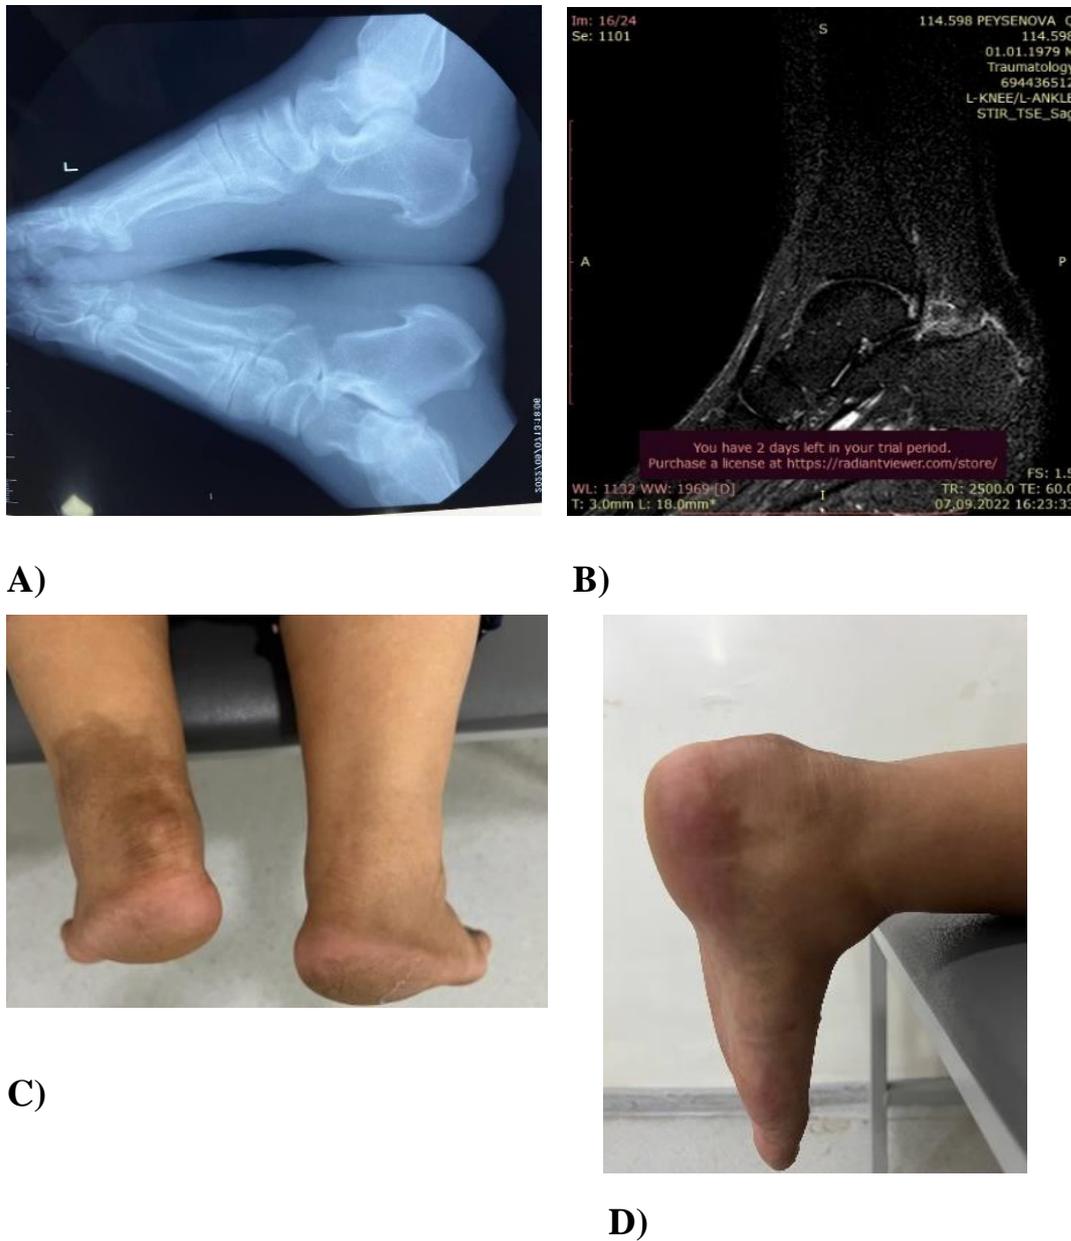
Haglund's deformity and Achilles bursitis. A) X-ray and B) MRI picture. C and D) Clinical view.
